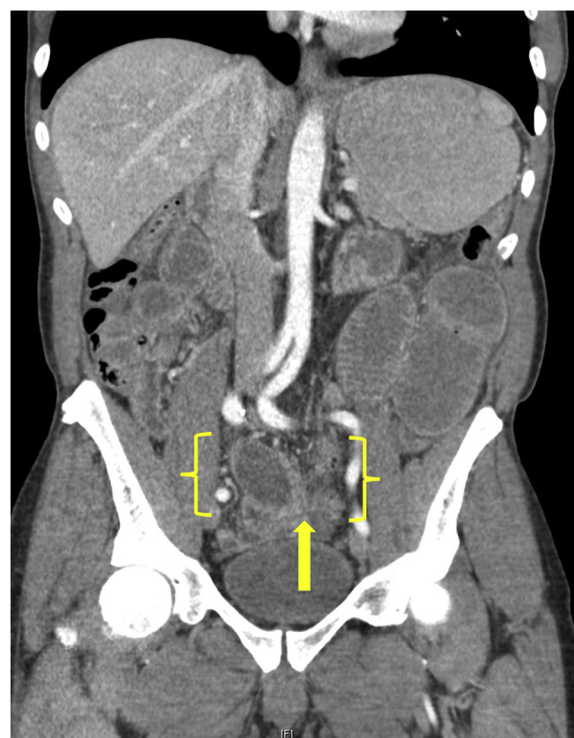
Computed tomography demonstrating obstructive intraluminal mobile leiomyoma. Note the homogenous appearance. Typically, indigestible masses that cause obstruction present with a mottled gas appearance. Arrow denotes transition point.
